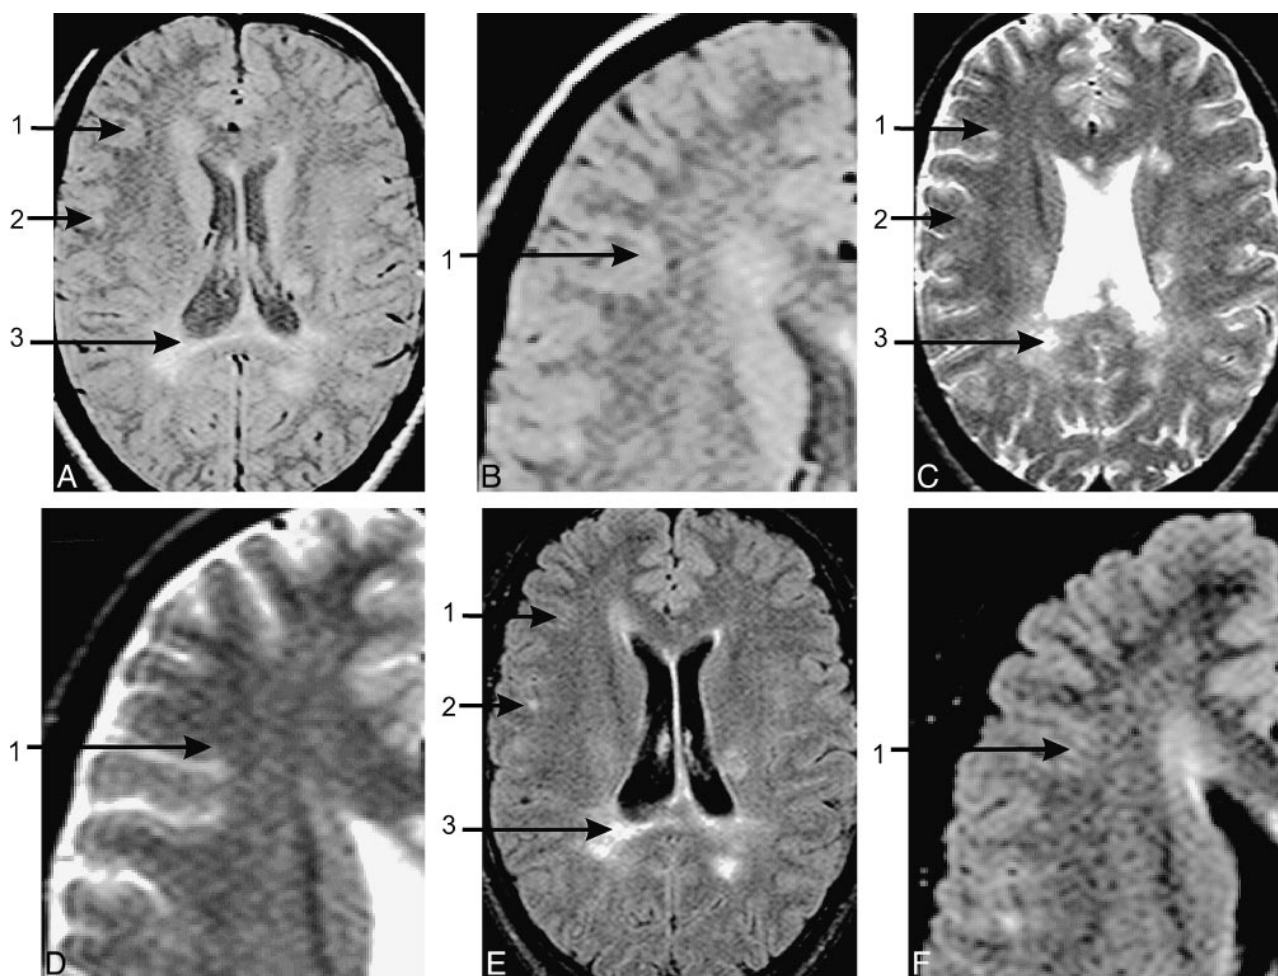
A–F, Matching lesions on proton density-weighted (A), T2-weighted CSE (C) and fast FLAIR (E) images. 1 denotes a population of lesions in the gray matter, extending to the juxtacortical boundary, which are evident on fast FLAIR but not on proton density— or T2-weighted CSE images. These lesions are further demonstrated on the magnified ($\times 2$) proton density-weighted (B) T2-weighted CSE (D), and fast FLAIR (F) images. 2 indicates a population of lesions that are less conspicuous on proton density— and T2-weighted CSE images (C). 3 relates to a medium-sized white matter lesion that is obvious on all imaging sequences.
